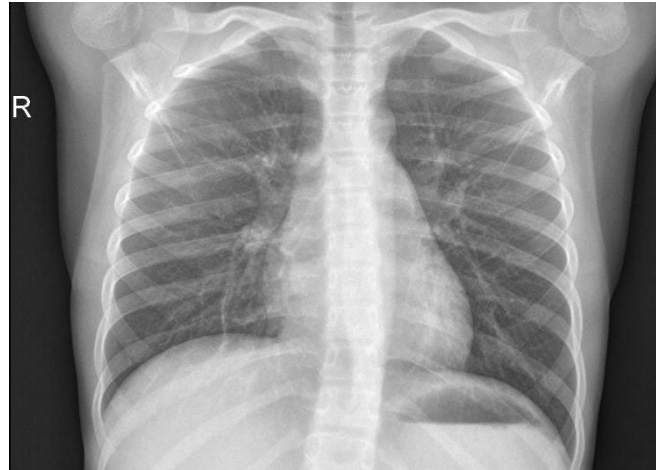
Chest X-ray image of a sick person because of virus shown in Figure 1c.
